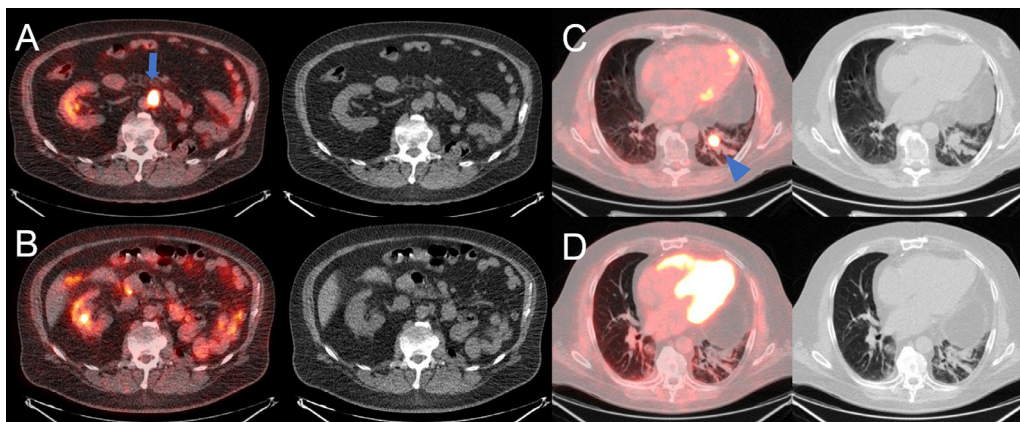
A 70-year-old man was diagnosed with grade 4 RCC with rhabdoid differentiation, underwent robotic left radical nephrectomy. Six months later while on immunotherapy with sunitinib, FDG PET/neCT was negative for residual or recurrent disease (not shown). However, at 12-month follow-up PET/neCT imaging, he developed a new FDG avid left lower lobe pulmonary nodule, 1.9 × 2.0 cm with max. SUV 8.1 (C, axial images; arrowhead) and a new FDG avid left paraaortic node, 2.0 × 2.4 cm with max. SUV 9.4 (A, axial images; arrow); reference liver SUV was 2.8. The retroperitoneal node was recurrent RCC at subsequent core needle biopsy. The therapy was switched from sunitinib to ipilimumab and nivolumab. PET/neCT four months later showed resolution of the paraaortic node (B, axial images) and pulmonary nodule (D, axial images), indicating complete treatment response.
